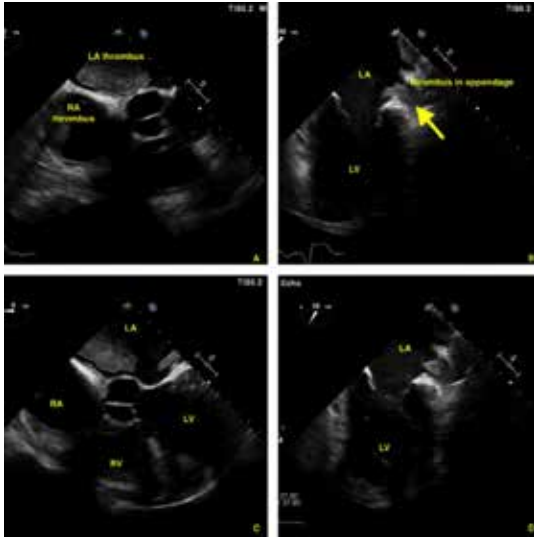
(A-D) Showing giant left atrial thrombi in transesophageal echocardiography.
